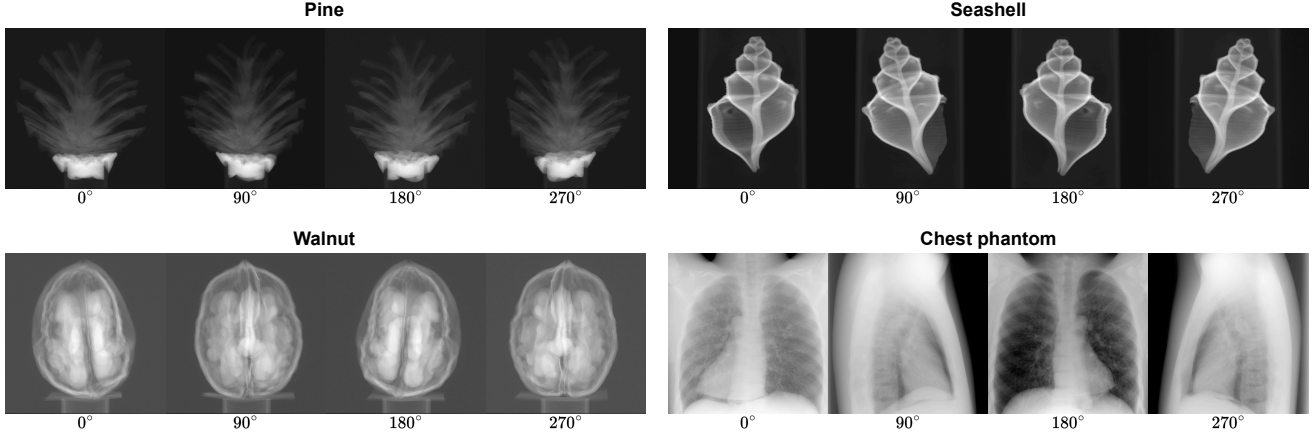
Real-world CBCT datasets used in our experiments. Representative projection images are shown for each case.
